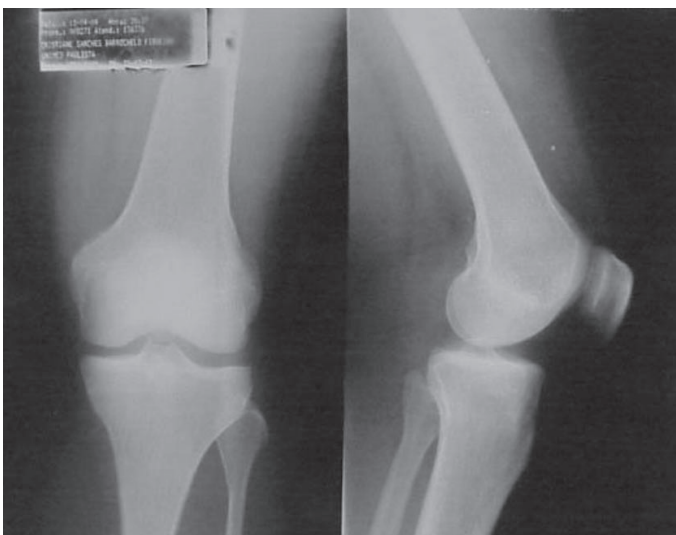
X-ray image of the left knee at AP and Lateral planes
